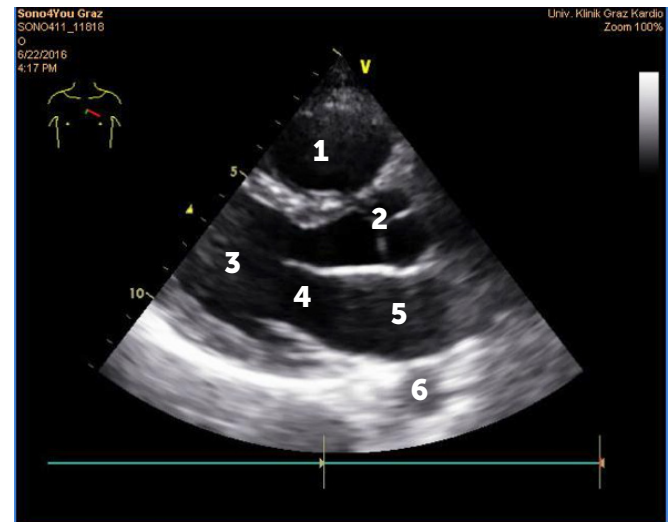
Parasternal long axis.
